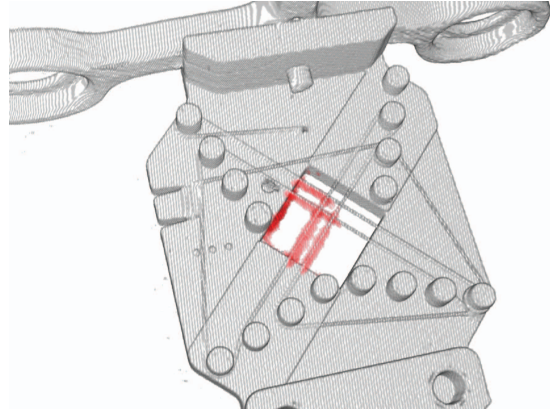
US acquisition (red) overlaid on the CT volume in accordance with the calibrated transformation $\mathbf{T}_{US,f}^a$.
